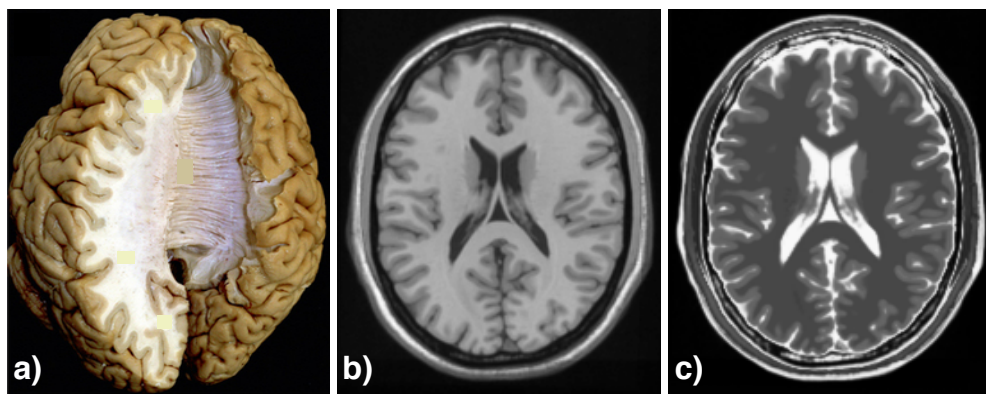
Brain tissue as seen in a dissected human brain^[119] (a), T_1 -weighted MRI (b), and a T_2 -weighted MRI (c). The GM appears darker in the dissected brain, and surrounds the WM tissue, which is lighter in appearance. The GM and WM of the brain can also be distinctly seen as the grey and white regions, respectively, in the T_1 -weighted image. In the T_2 -weighted image, however, the WM appears darker than the GM. The acquisition of MRI images with various contrasts is described in Chapter 3.
